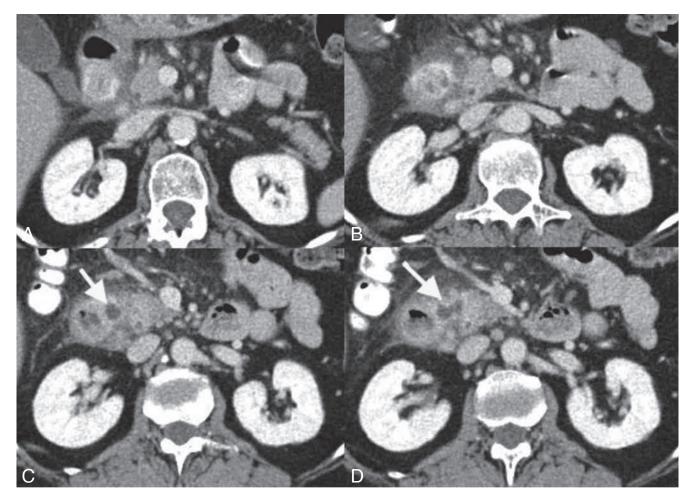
Venous-phase CT abdomen in a 54-year old woman with pure groove pancreatitis. Images from cranial to caudal show a hypodense sheetlike mass in the groove between the pancreatic head and the duodenum (A) and extensive infiltration of the paraduodenal fat (B). There is thickening of the medial duodenum wall and a cyst in this thickened duodenal wall extending to the groove area (white arrows) (C-D).
